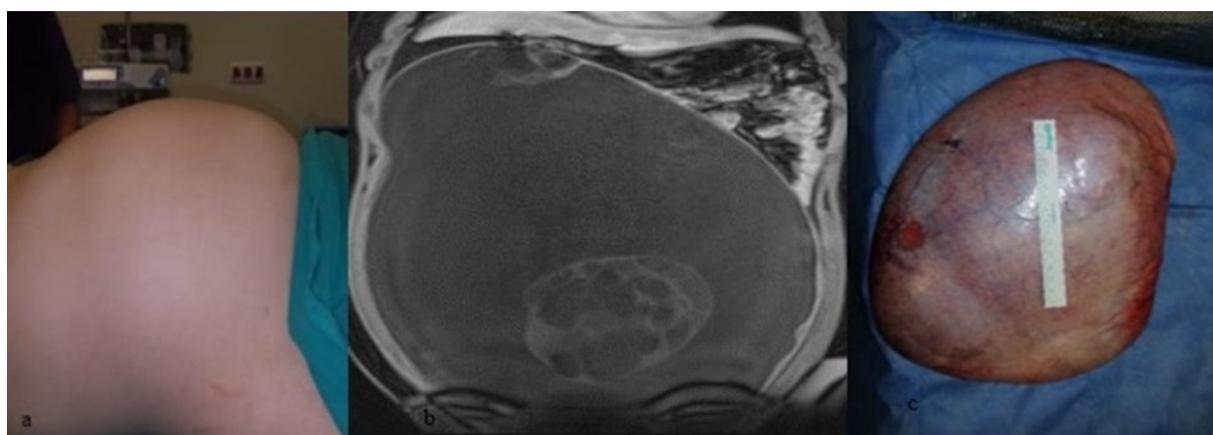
1a: The appearance of the abdomen before the operation in the first case by inspection; 1b: MRI of a huge mass filling the entire abdomen; 1c: The postoperative appearance of the huge, smooth surface cystic mass.
